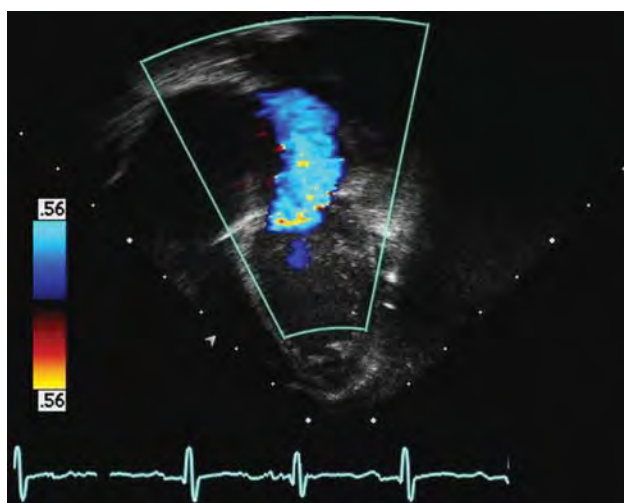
Echocardiography: four-chamber view obtained from a 15-day-old infant presenting with respiratory distress, with color Doppler. Note the significant degree of mitral regurgitation related to the ventricular dysfunction. In this case, the relatively normal appearing left ventricle (LV) size suggested an acute process causing the dysfunction.
